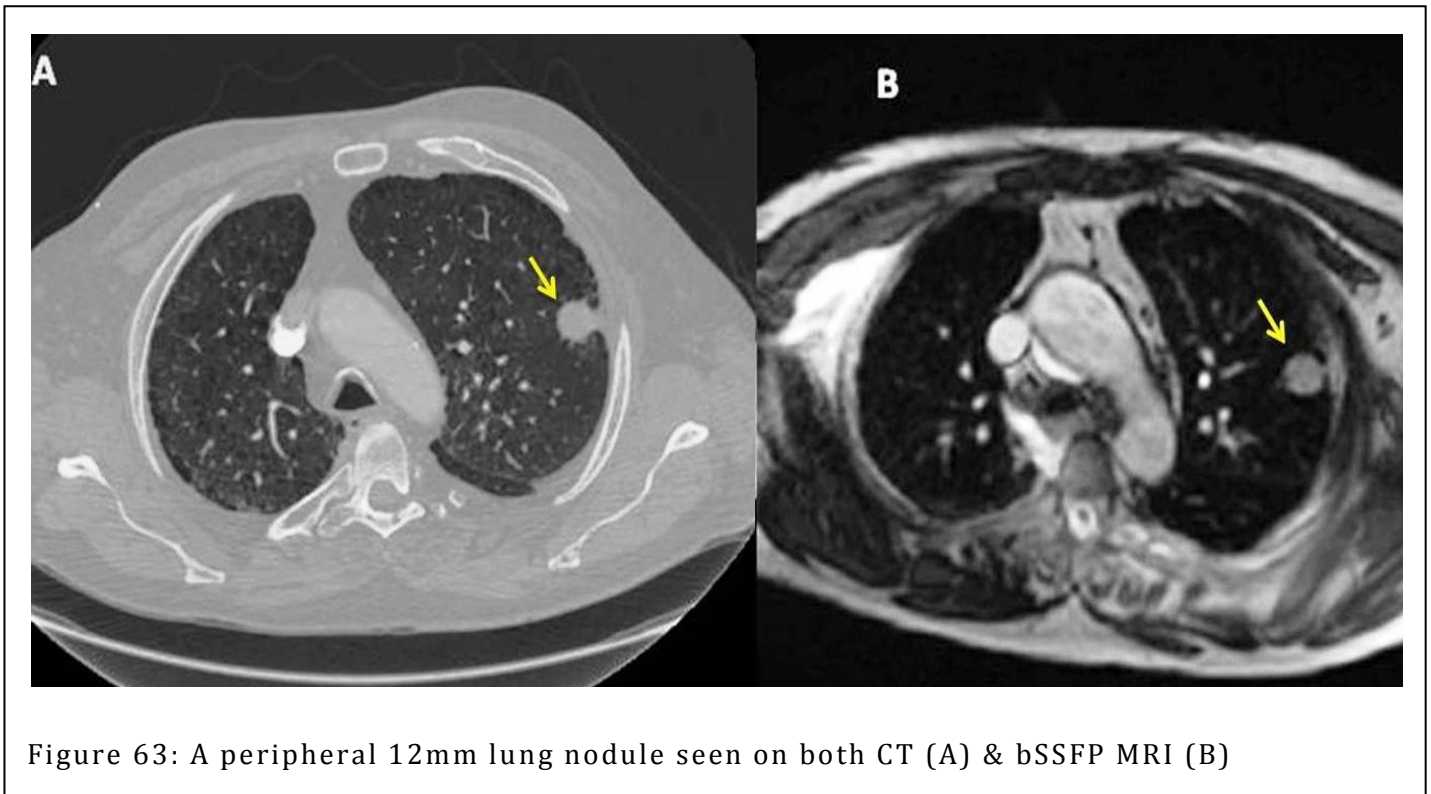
A peripheral 12mm lung nodule seen on both CT (A) & bSSFP MRI (B)
